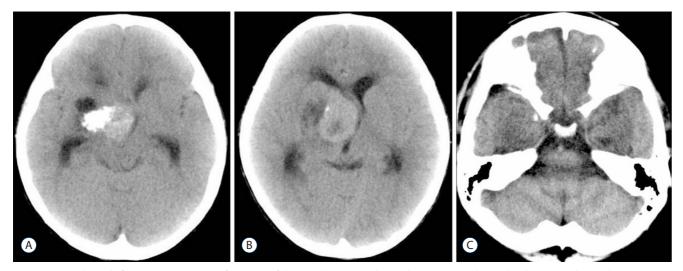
CT revealing calcification, necrosis, cystic formation of the mass lesion (A and B). No hyperostosis or bone absorbtion was observed (C).
